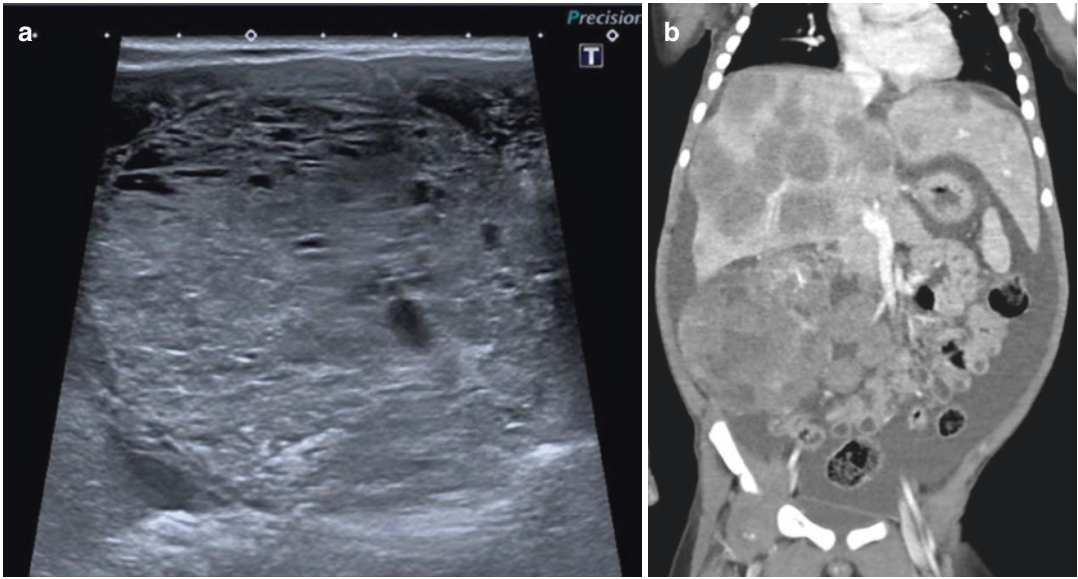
Extrasosseous Ewing’s sarcoma 1-year-old boy. (a) US Transverse scan of the left flank—An echogenic microcystic mass is demonstrated. (b) CE-CT Frontal reformatted view. The lobulated mass enhances partially; there are liver metastases and ascites
